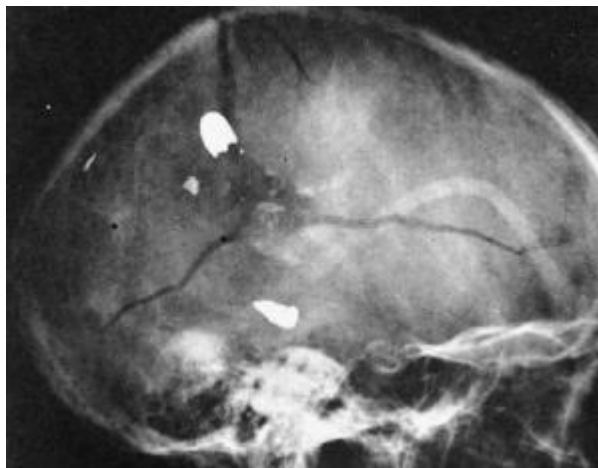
Skull X-Ray showing gunshot point of entry and associated fractures
